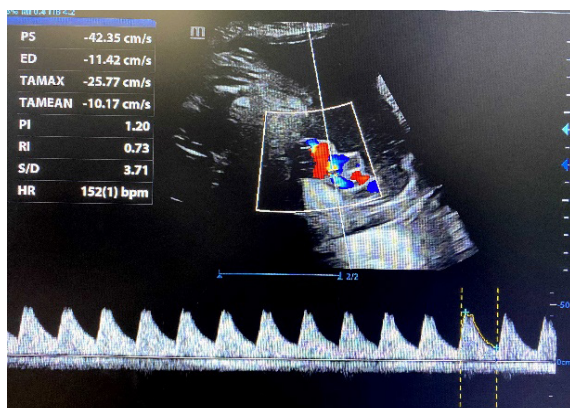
Ultrasonography Findings of Dilated Cardiomyopathy
